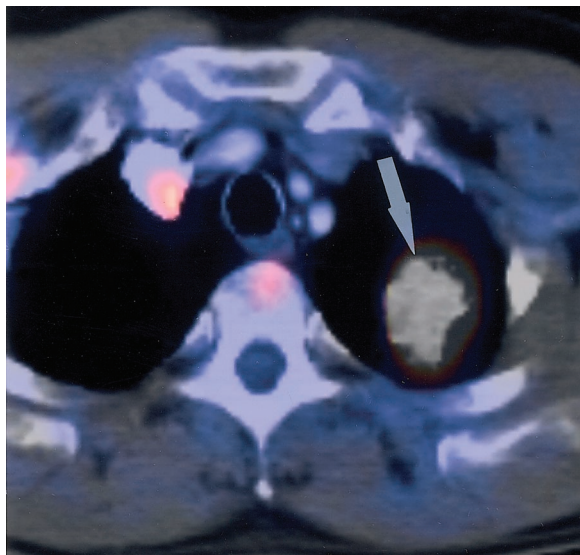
Adenocarcinoma in a 50-year-old man with a mass in the apex of the left lung. Results of multiple biopsies were negative for malignancy. FDG PET-CT was performed for further characterization of the mass. Axial fused FDG PET-CT image shows marked hypermetabolism in the lesion (arrow), which proved to be a poorly differentiated adenocarcinoma at subsequent left upper lobectomy.
